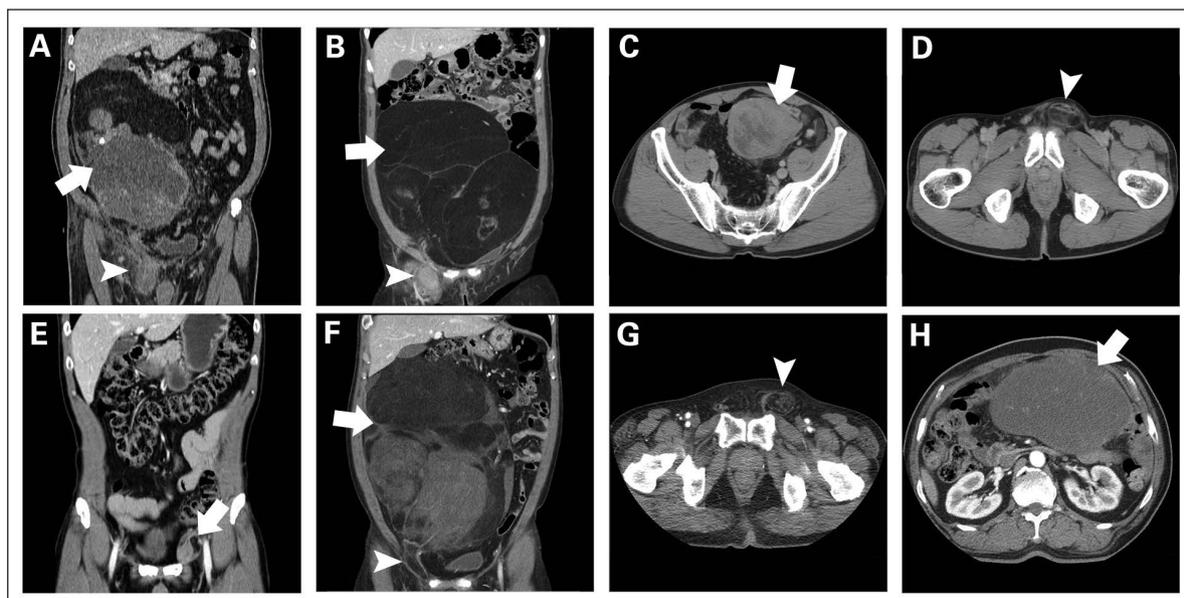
Computed tomography scans of patients with retroperitoneal liposarcoma extending into the inguinal canal. A) Patient 1 had a 28 cm mass occupying the right hemiabdomen with right inguinal protrusion. B) Patient 2 had a 30 cm mass occupying the entire abdomen with right inguinal protrusion. Patient 3 had C) an 18 cm mass in the pelvis reaching to the lower pole of the left kidney D) with extension through the left inguinal canal. E) Patient 4 had a 22.5 cm mass in the pelvis with protrusion through the left inguinal canal. F) Patient 5 had a 32 cm mass occupying the entire abdomen with protrusion through the right inguinal canal. Patient 6 had G) a protrusion through the left inguinal canal H) that originated from a 37 cm mass occupying the left hemiabdomen. Arrows indicate the mass of origin, and arrowheads indicate protrusion of the mass in the inguinal canal.
